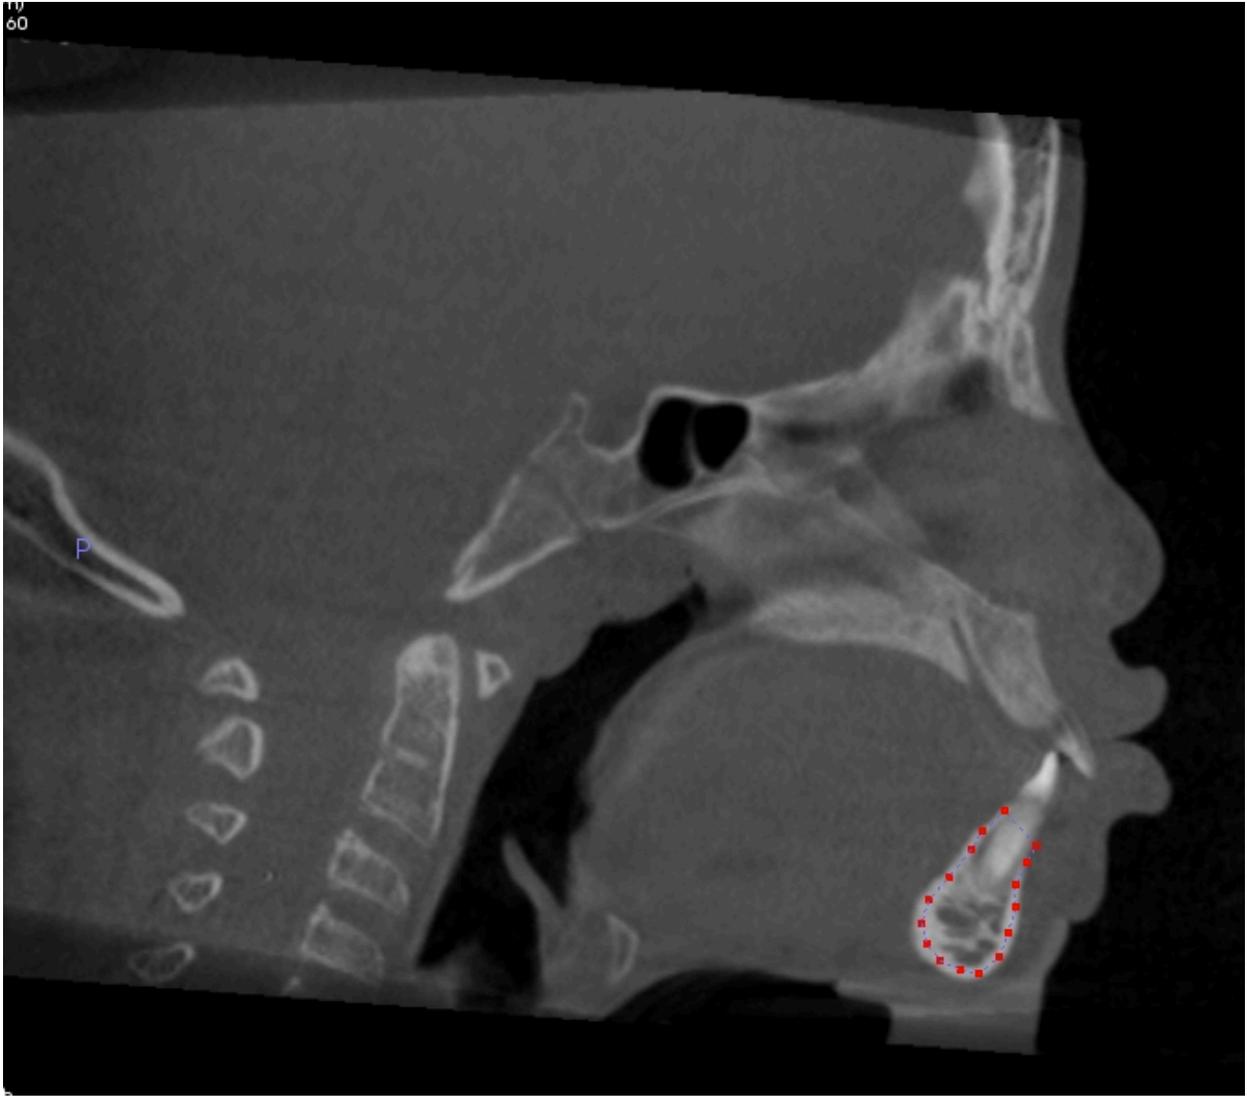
The midsagittal slice of the CT scan is located between the two maxillary central incisors. Anatomage software is used to outline the visible mandibular symphysis.
